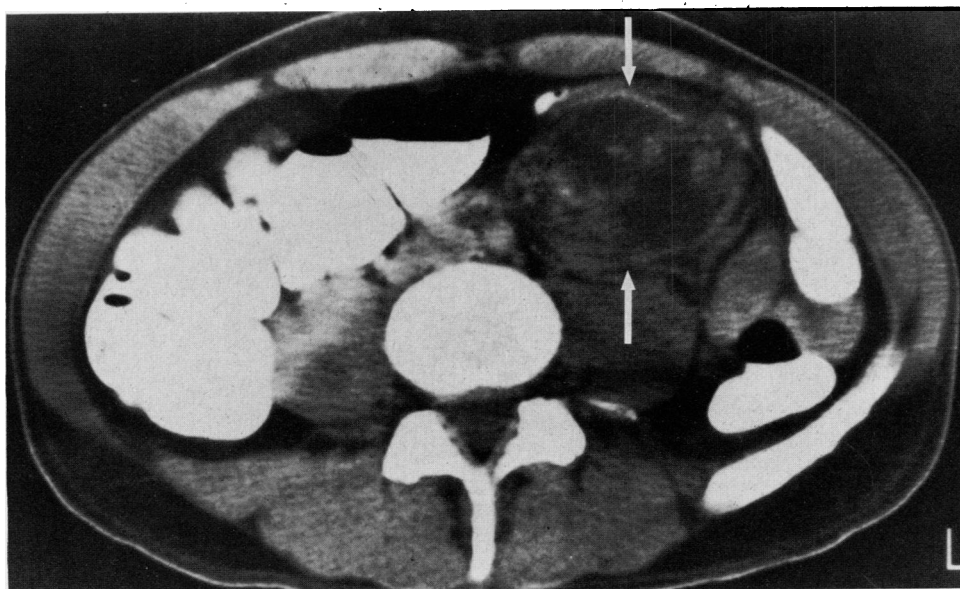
A computed tomographic scan shows a mesenteric mass (arrows) containing areas of soft tissue and water density. There is a surrounding rim of soft tissue.
